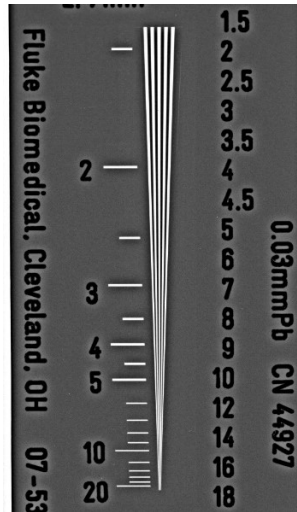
10. X-ray image of the angle resolution pattern taken with 60kV.
